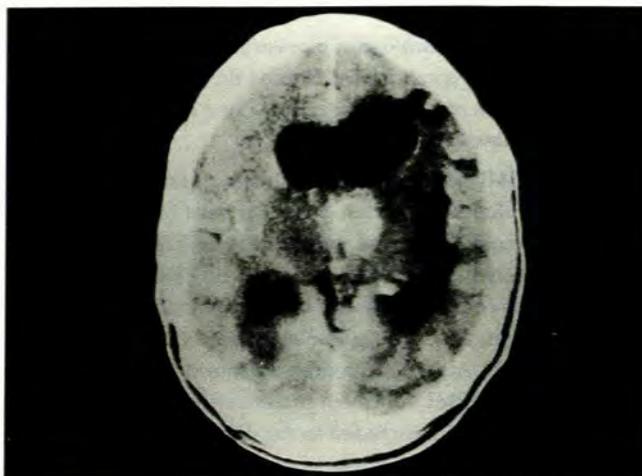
Mass on this CT scan found to be due to toxoplasmosis.
